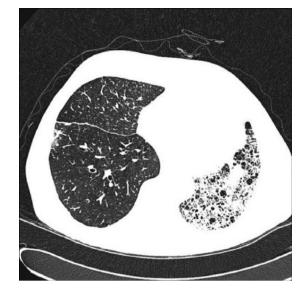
Chest CT of a patient with right unilateral lung transplant due to pulmonary fibrosis.
